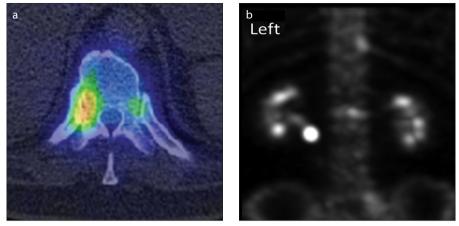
a, b. SPECT-CT images of a 68-year-old man with low back pain and increased ^{99m}Tc MDP activity. Panel (a) shows increased bone tracer activity at the right 10th costovertebral joint. The patient had midline tenderness in the lumbar spine, but no pain corresponding to the right 10th costovertebral joint. Panel (b) shows additional areas of increased activity including an L1-L2 anterior osteophyte and the left L5-S1 facet joint. The right 10th costovertebral joint did not undergo injection.
